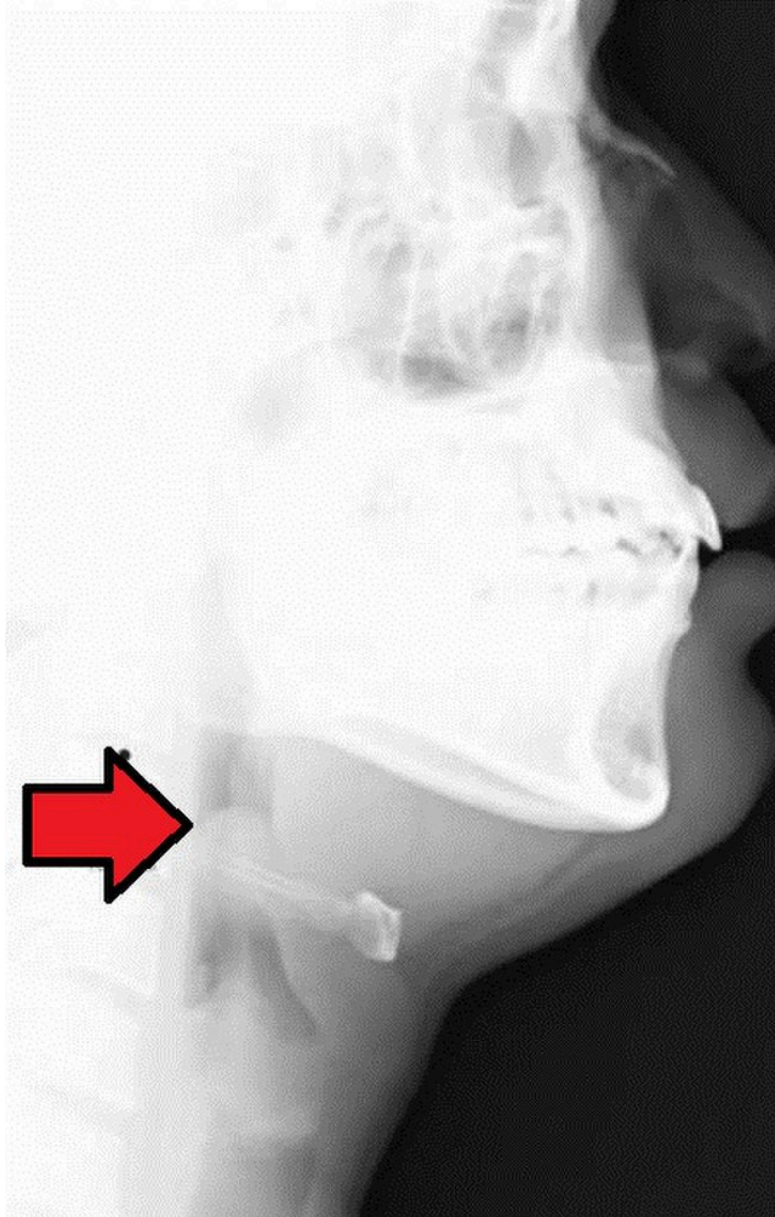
Lateral Neck X-Ray Demonstrating a Swollen Epiglottitis
